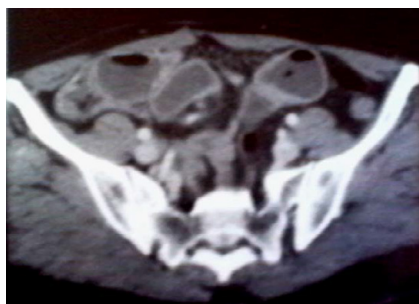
Computed tomographic: distended small bowel.
